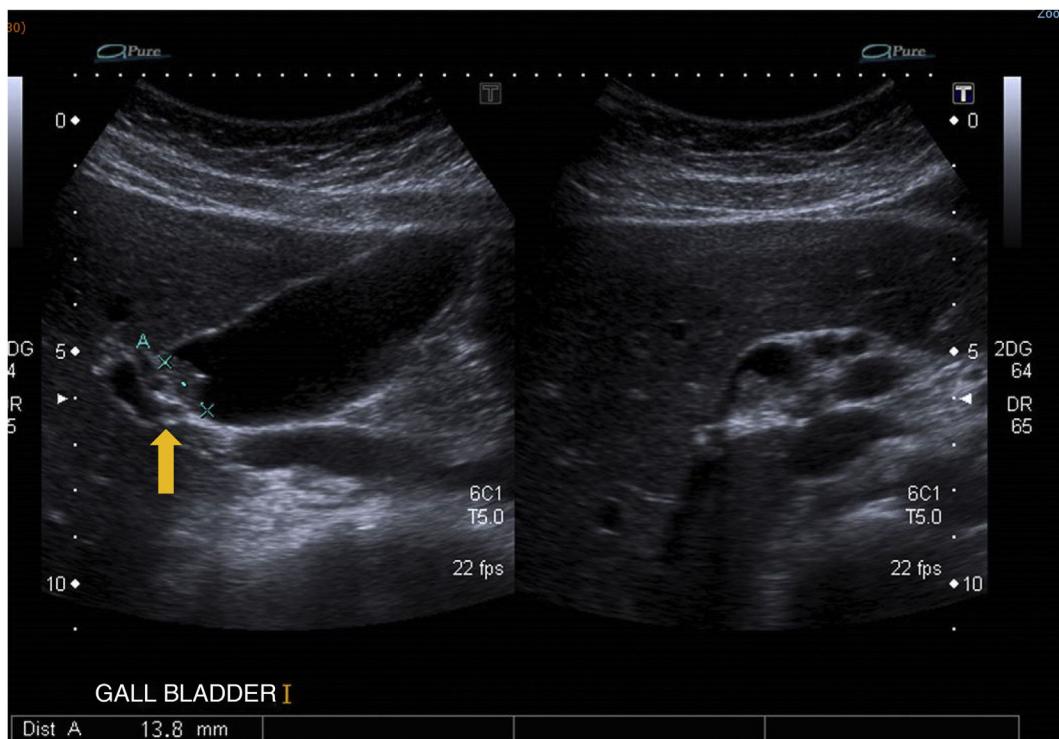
Abdominal ultrasound showing a sessile hypoechoic image in the gallbladder with a peripheral calcification 13 mm in size, consistent with a polyp (indicated by the arrow).
